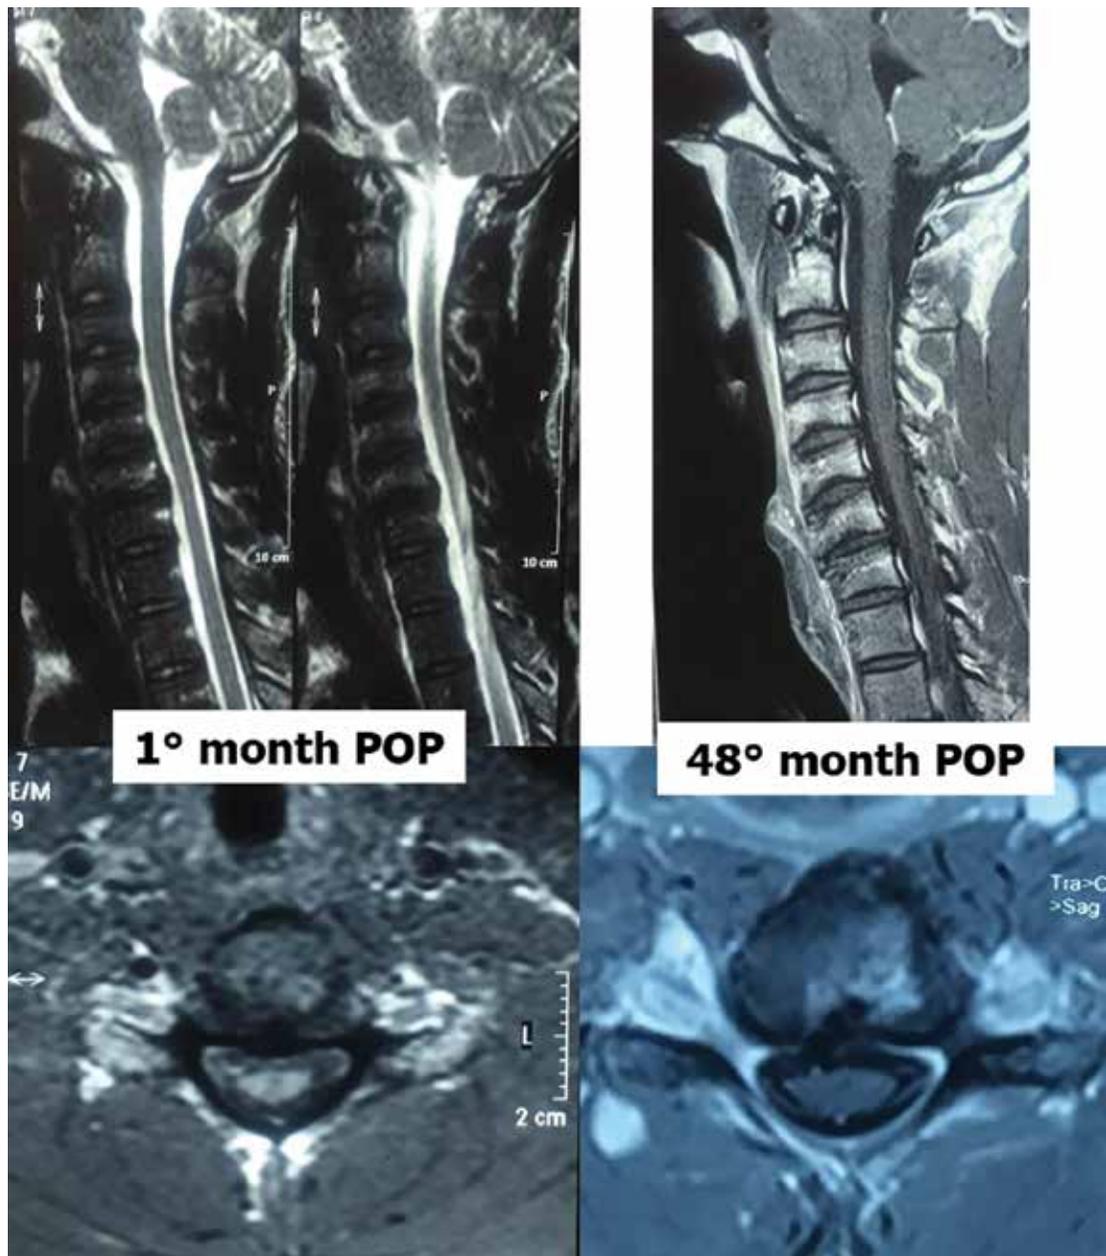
Postoperative MRI showing complete decompression of cervical IDH.
